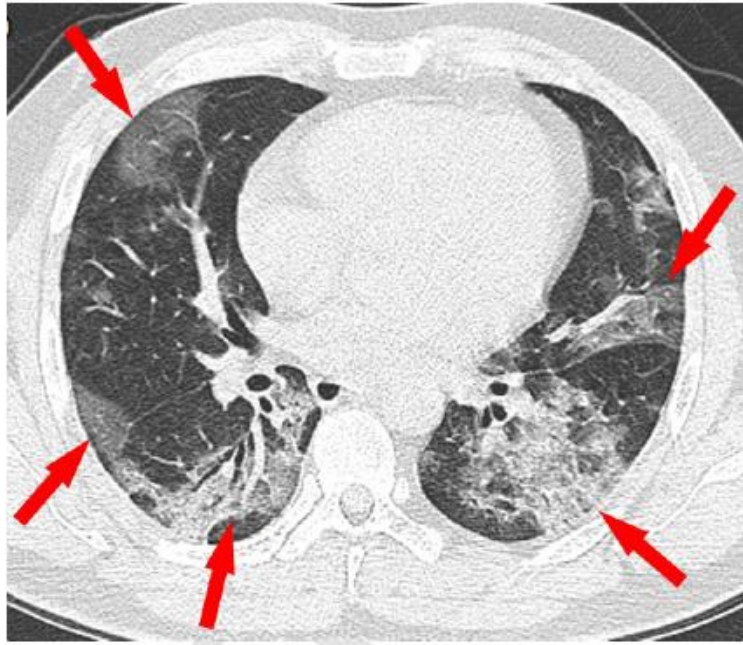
CT findings of confirmed Coronavirus Disease 2019 (COVID-19) pneumonia Consolidation pattern. A 17-year-old male presented with fever (38.1°C, 100.58°F), cough for three days, and Wuhan exposure history. Axial unenhanced chest CT acquired on January 27, 2020 showed multiple pure consolidation lesions (arrows) in the middle lobe of right lung and upper lobe of left lung.
